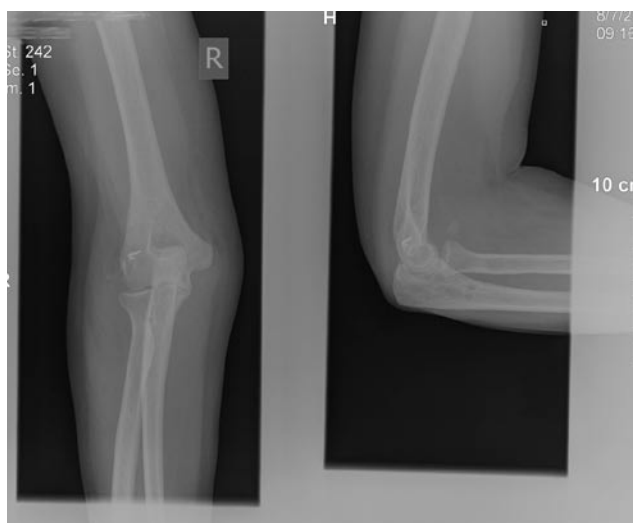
Four-month lateral and anteroposterior radiographs show concentric reduction of radiocapitellar and ulnohumeral joints with slight residual anterior ossification unchanged from original presentation radiographs.
